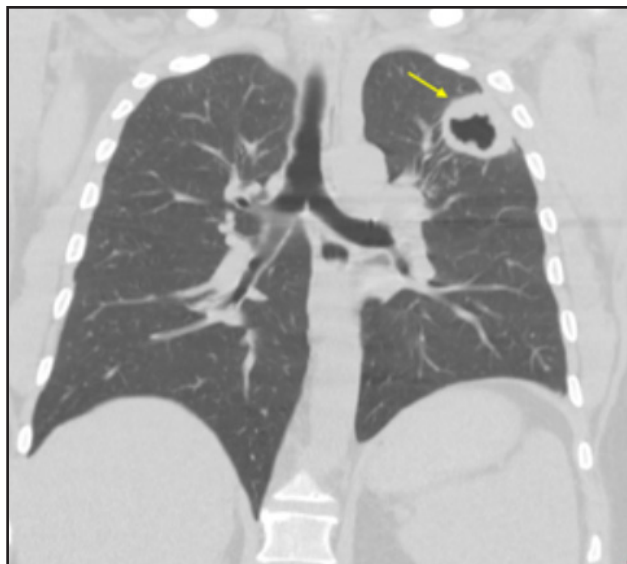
Postprimary pattern tuberculosis. Coronal noncontrast CT image demonstrating cavitation with a thick nodular wall (yellow arrow) involving the left upper lobe apicoposterior segment.
